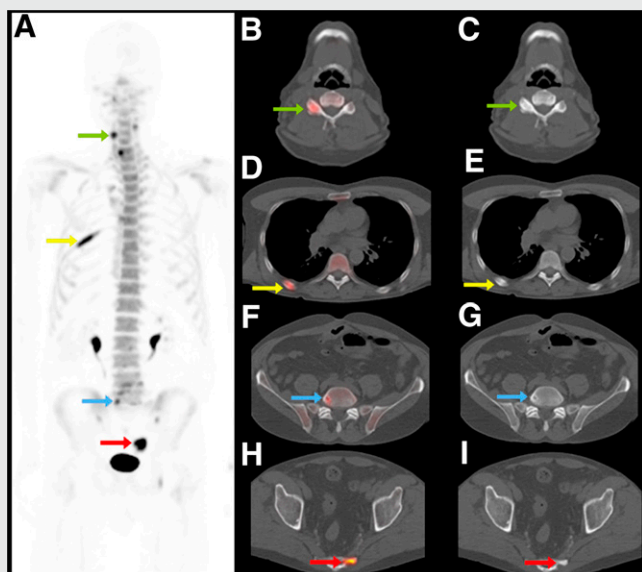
Maximum-intensity-projection PET image (A) and selected axial PET/CT (B, D, F, H) and CT (C, E, G, I) images of ^{18}F -NaF PET/CT scan of 63-y-old man with prostate cancer. Increased ^{18}F -NaF uptake can be seen in benign changes of right cervical facet joint (green arrow in A, B, and C), healing rib fracture (yellow arrow in A, D, and E), benign lumbar vertebral bone cyst (blue arrow in A, F, and G), and blastic metastasis in sacrum (red arrow in A, H, and I). Additional value of CT to characterize focally increased tracer uptake is evident.
